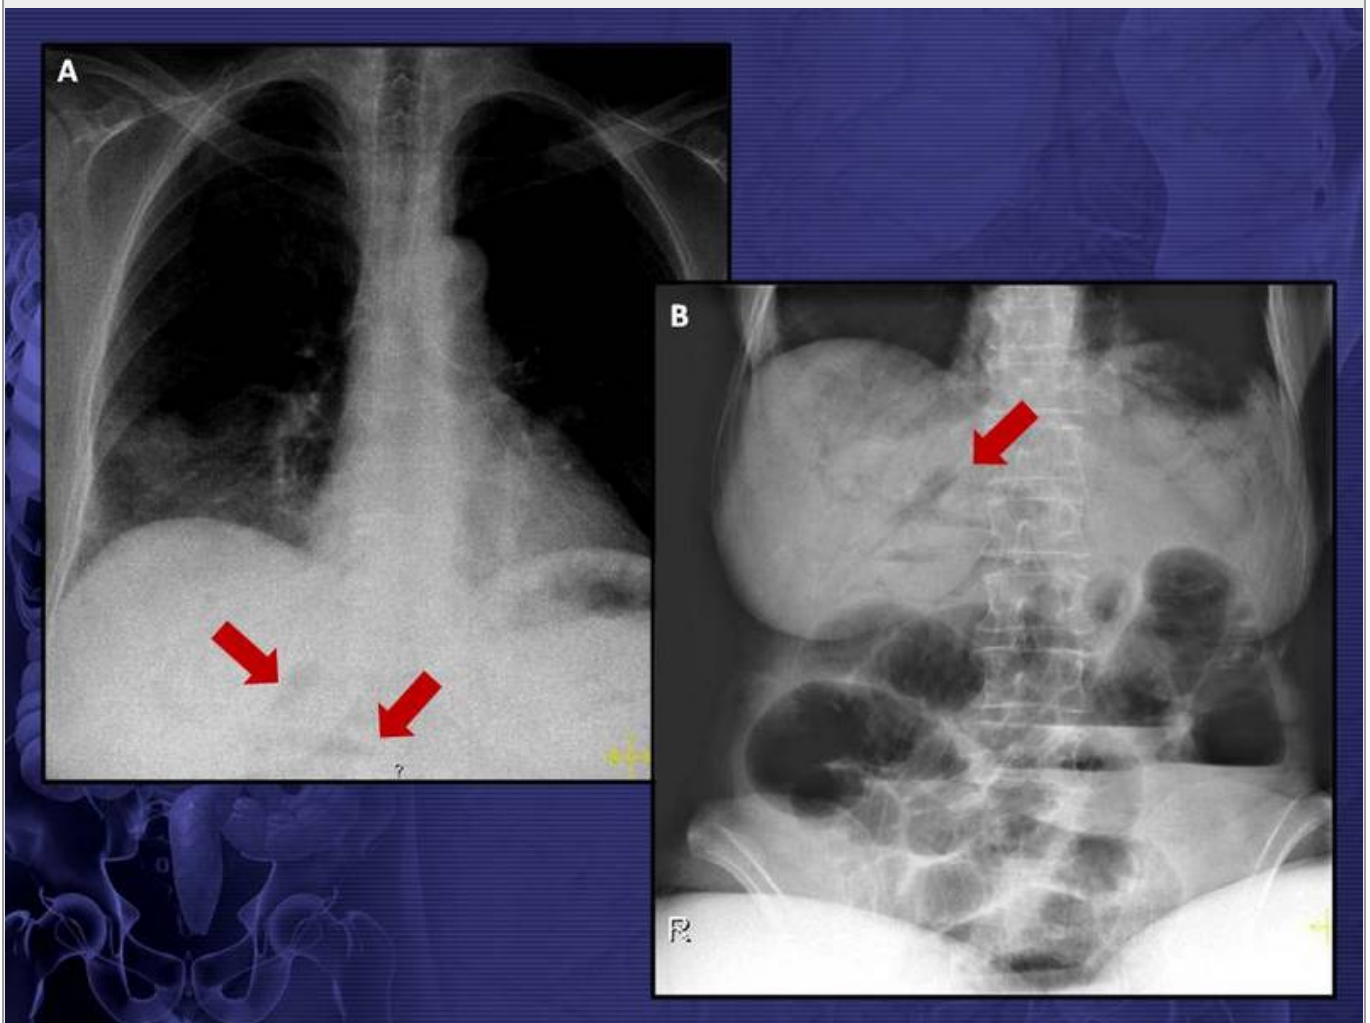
(A) Frontal chest radiograph of this 73-year-old lady raised the suspicion of portal venous gas. (B) Abdominal x-ray findings were even more suggestive. The patient was submitted to surgery, which confirmed acute mesenteric ischemia.
